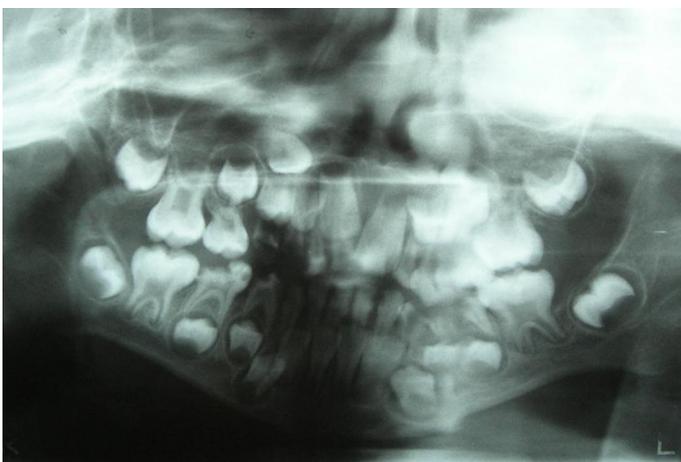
Preoperative radiograph showing teeth.
